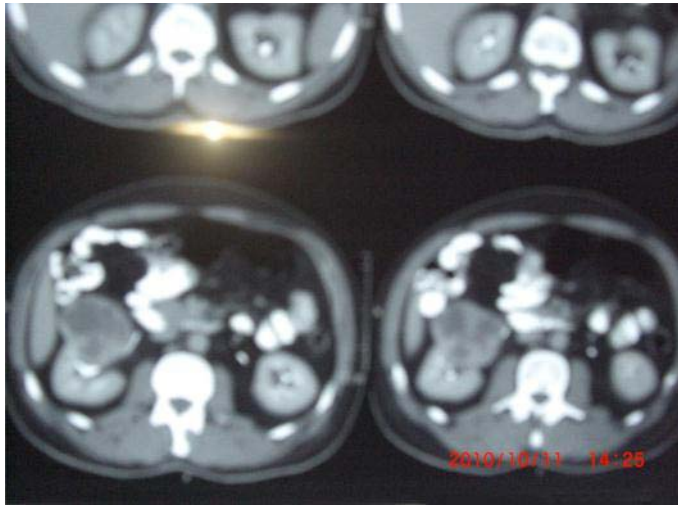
Abdominopelvic contrast-enhanced CT scan, revealing the right renal upper pole heterogeneous mass.
